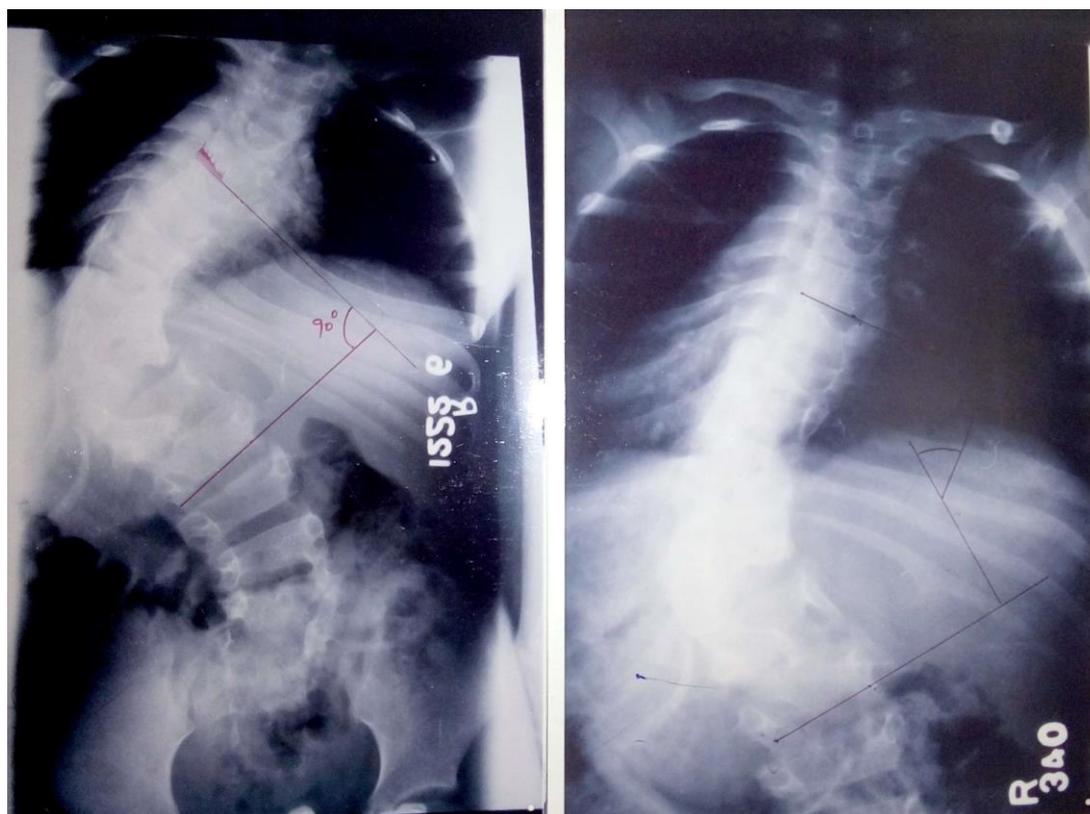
(a&b) Chest X-ray pre-operative (a) and after removal of Halo-pelvic Traction. (b)
